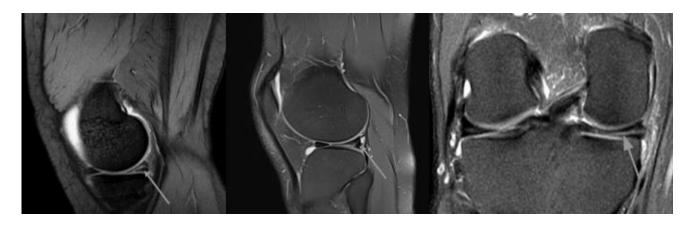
Sagittal and coronal magnetic resonance images showing abnormal (high) signal intensity (arrows) into the meniscus extending to the articular surface.
